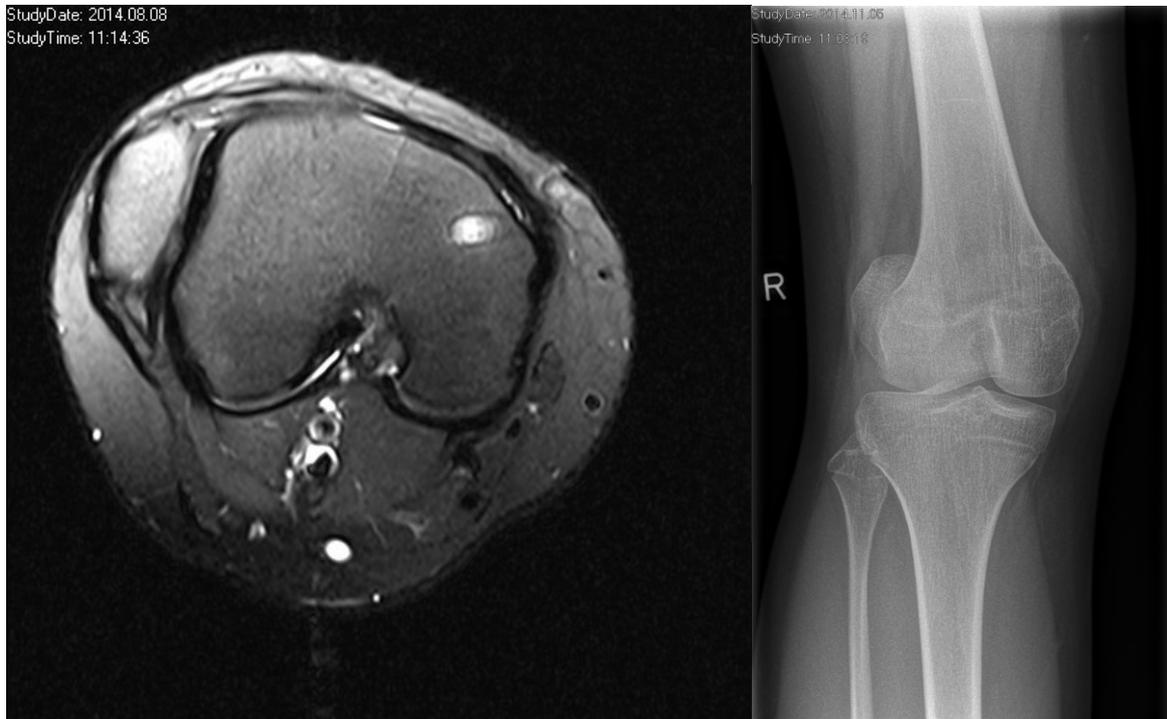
Although radiographs offer valid information about the general condition of the knee, MRI is an excellent tool in order to assess the patellofemoral joint more in detail.
